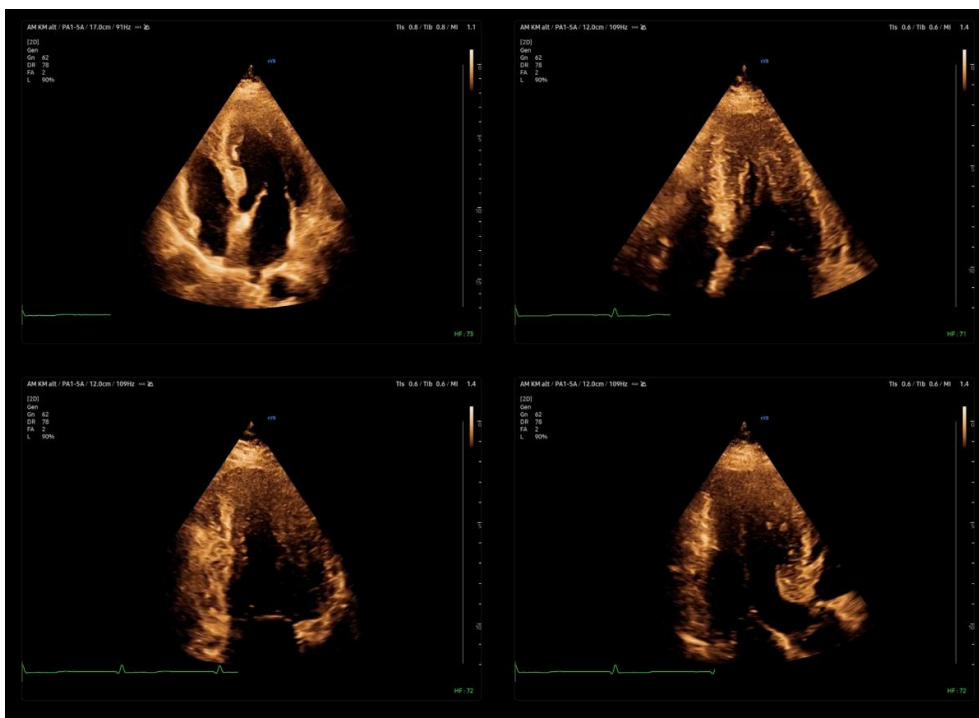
B-Mode Imaging in an apical 4-ChV as an overview, followed by apical focused views – 4-ChV, 2-ChV, and APLAX.
